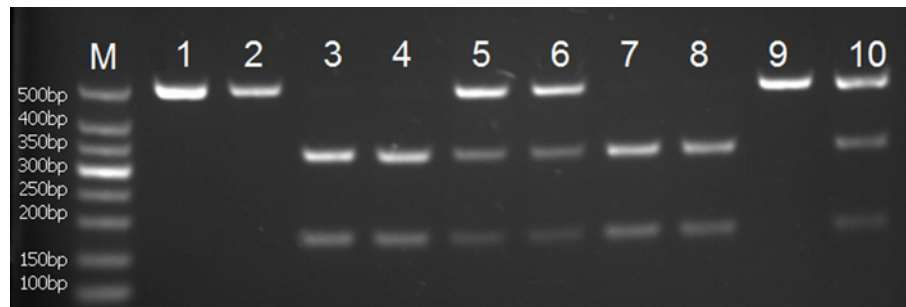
PCR-RFLP assay for analyzing the *rs1543297* polymorphisms of the *osteocalcin* gene. Lanes M: DNA Marker; Lanes 1, 2 and 9 show CC genotype; lane 5, 6, and 10 shows CT genotype; Lanes 3, 4, 7 and 8 show TT genotype.
